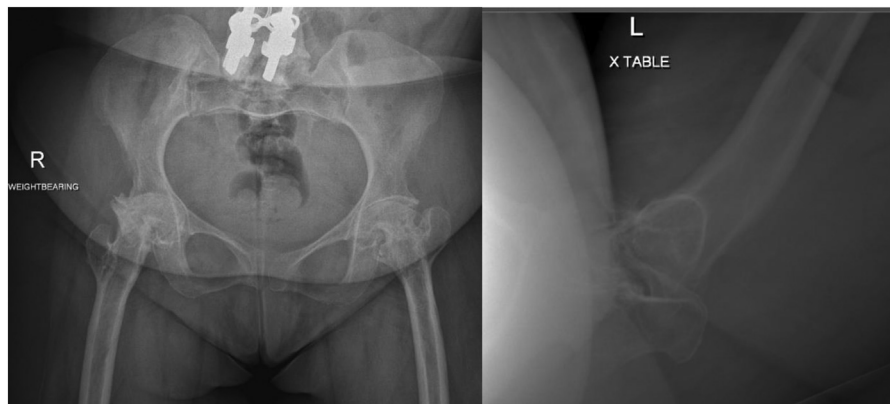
Preoperative standing anterior-posterior pelvis radiograph of the pelvis (Left) and cross-table lateral radiograph of the left hip (right).
